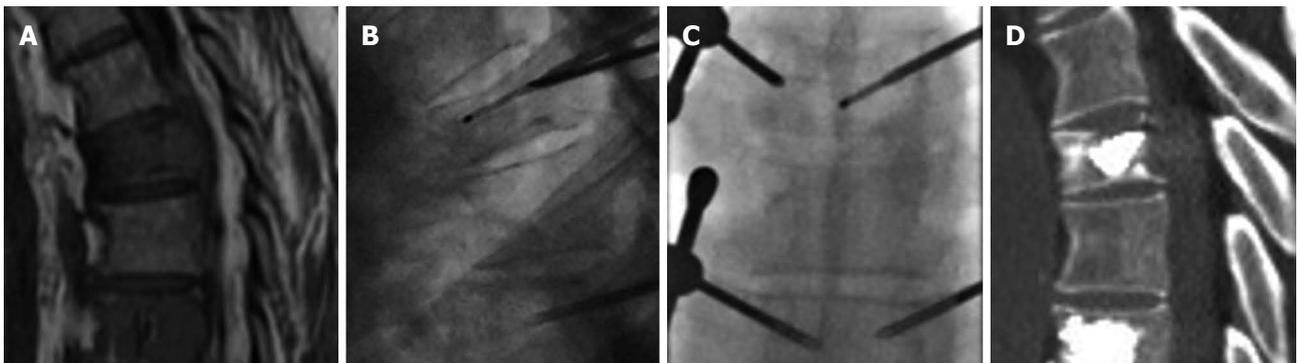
Sagittal magnetic resonance imaging T1 weighted image of a patient with vertebral metastases (A), radiofrequency thermal ablation was performed before cementation (B, C), post procedure computed tomography (D).
